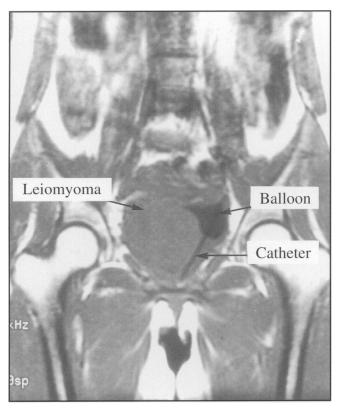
MRI Scan: Coronal (SE/TR500/TE11) – The mass shows a homogenous signal and appears to arise from within the bladder wall.
